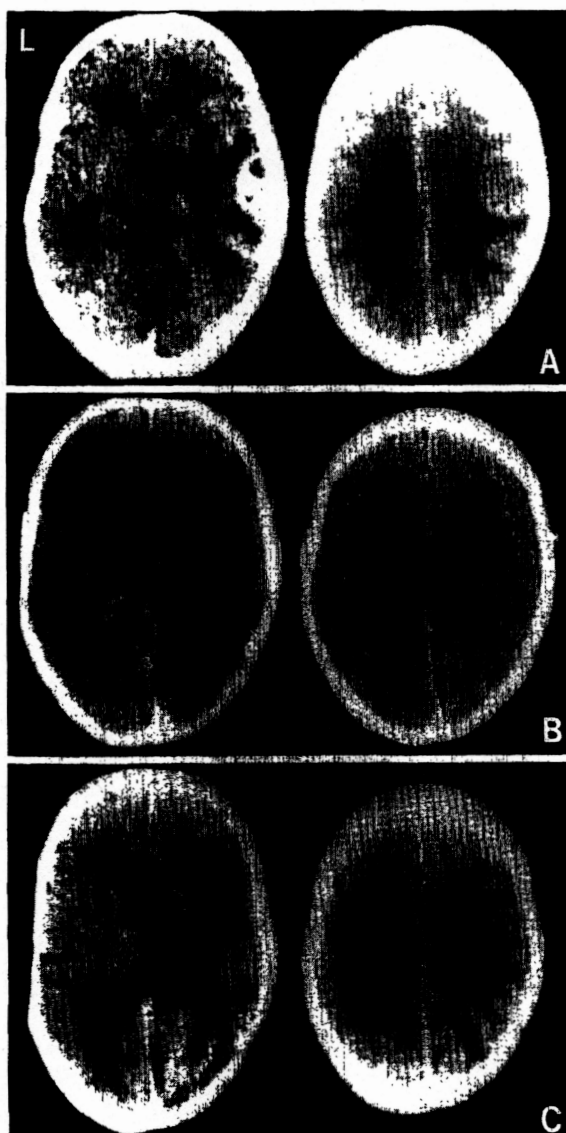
Sequential postcontrast CT scans in Case 1. A: On admission, an enhanced mass in the right temporal region is seen. B: At discharge, a rim of contrast enhancement is noted. C: At readmission, a diffuse low-density area with contrast enhancement and mass effect in the right white matter are shown.
